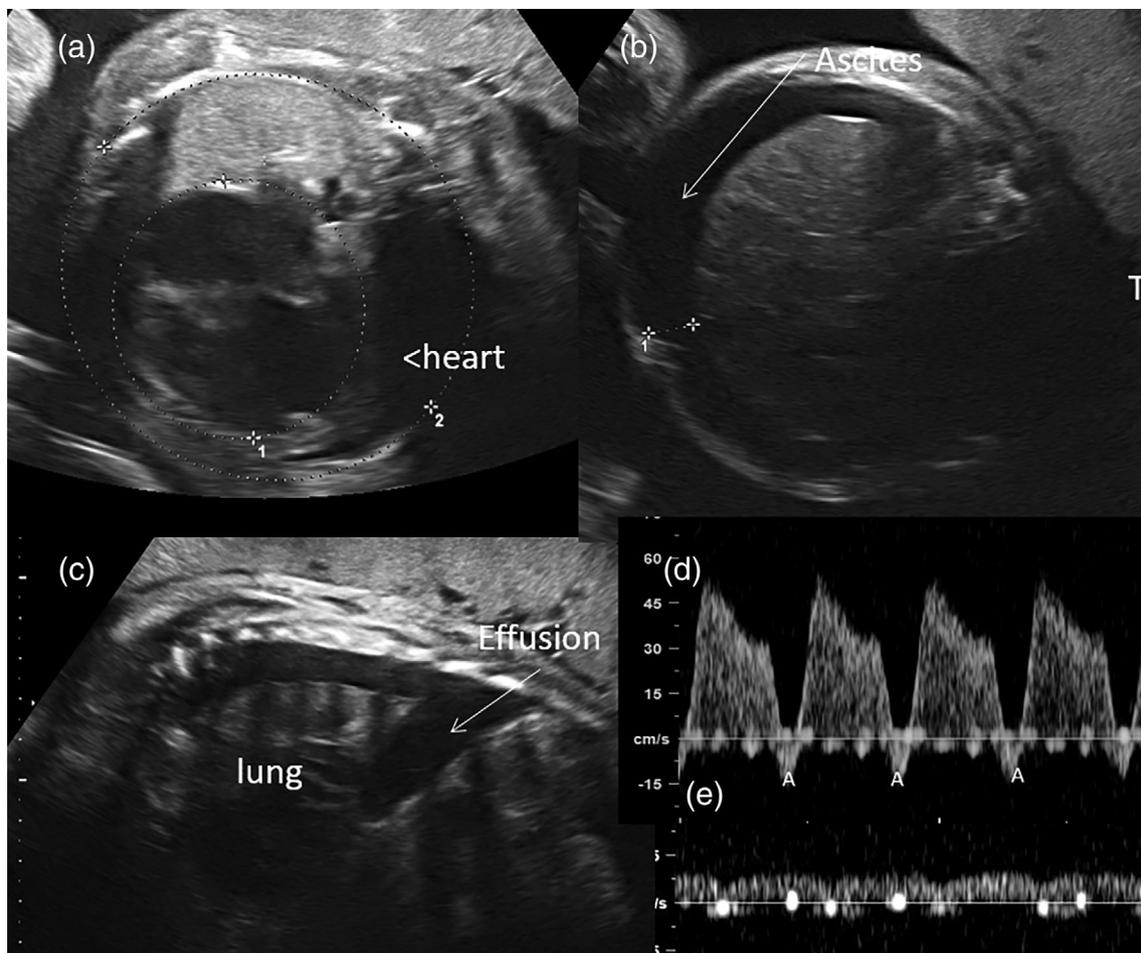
Prenatal echocardiogram: 33 + 1 weeks gestation. (a) Cardiomegaly (cardiothoracic ratio 62.5%, normally <50%); (b) Ascites; (c) Pleural effusion; (d) Abnormal ductus venosus Doppler with retrograde “a”-wave; (e) Pulsatile flow in umbilical vein and holosystolic regurgitation of both atrioventricular valves giving a cardiovascular profile score of 5, consistent with a poor prognosis
